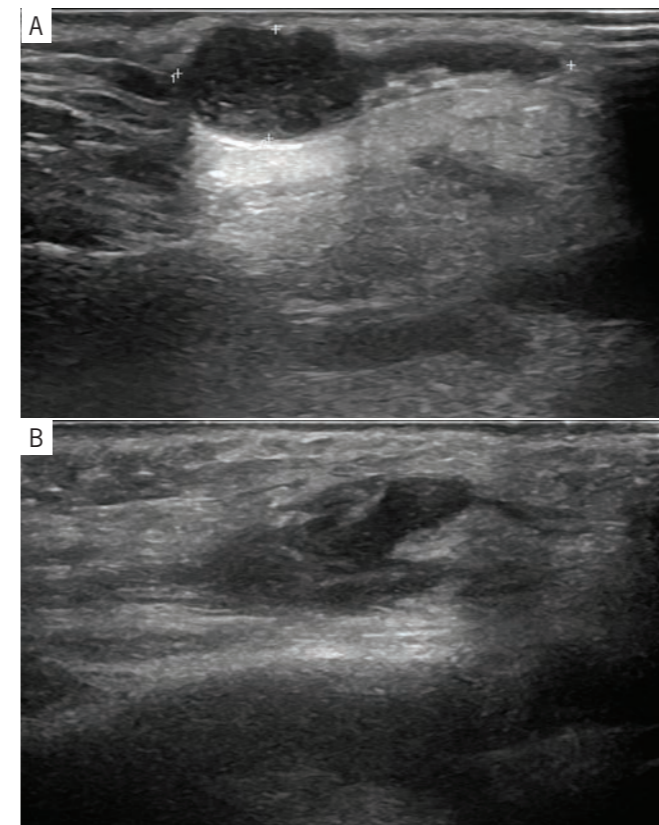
(A and B) Ultrasound reveals an anechoic well-defined thickened liquid formation with debris in suspension. In some patients, panniculitis of the surrounding subcutaneous tissue was observed. The collections were located in the Juvederm Volux® injection plane.
